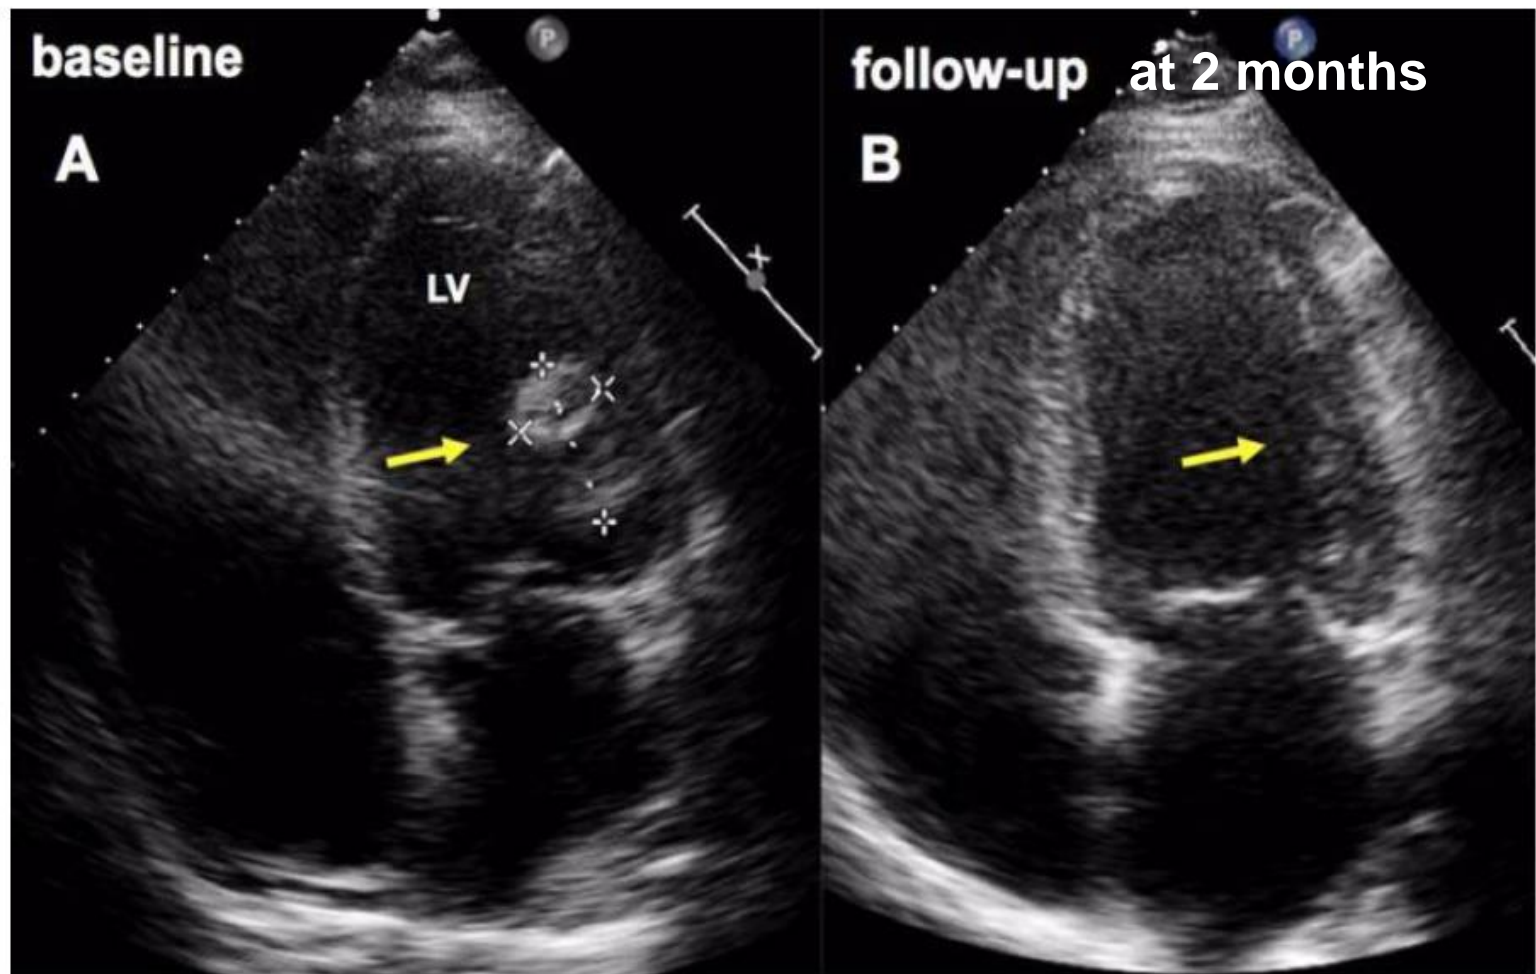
Four-chamber view on initial echocardiogram demonstrates a large thrombus (arrow) attached to the lateral wall of the left ventricle (LV) at baseline (A), which has completely resolved after two months (B).
